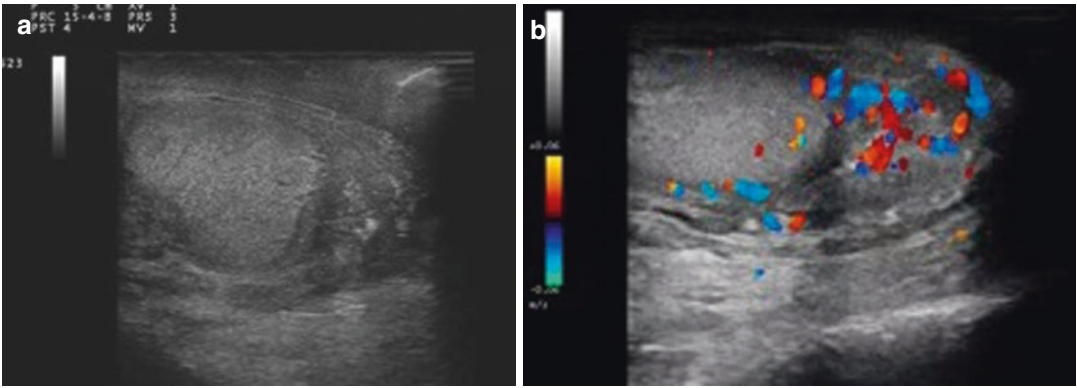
Acute epididymitis. (a) The greyscale US shows an enlarged tail with heterogeneous appearance. (b) Colour Doppler investigation reveals an increase of vascular flow
